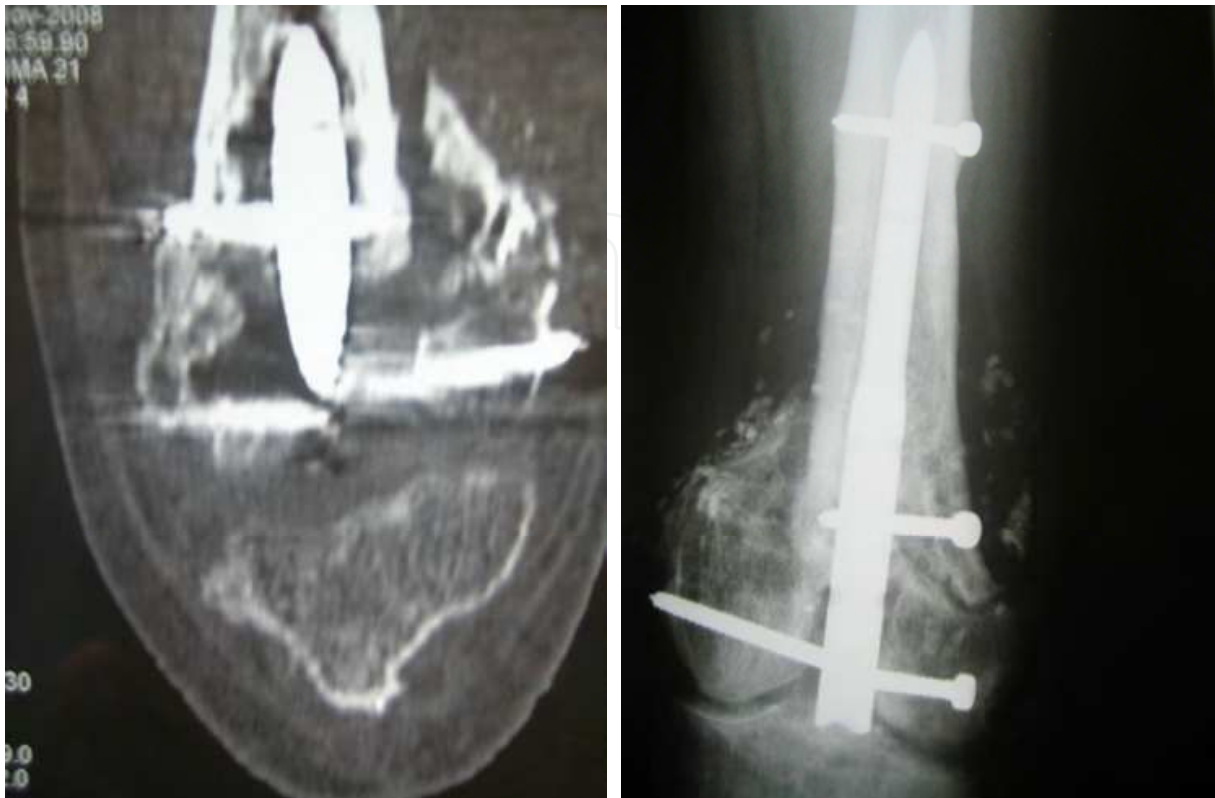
Frontal section computed tomography (left) showing nonunion of the distal femur, without any evident radiographic signs (right).
